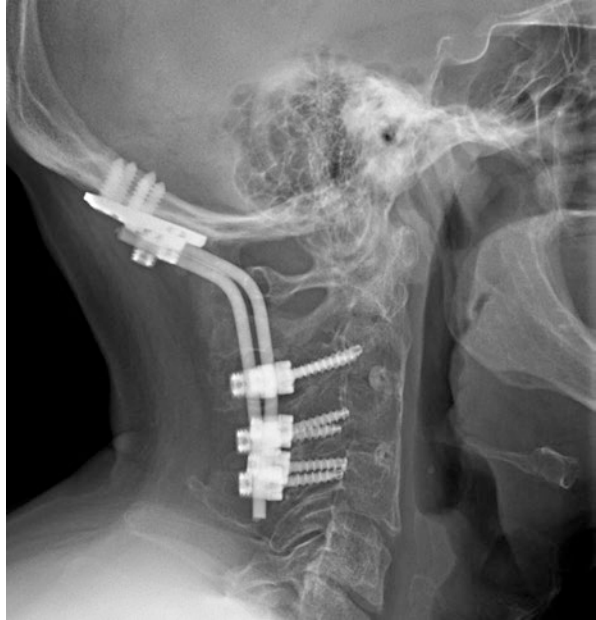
Two-year follow-up cervical X-ray showing fusion mass across the reconstruction
